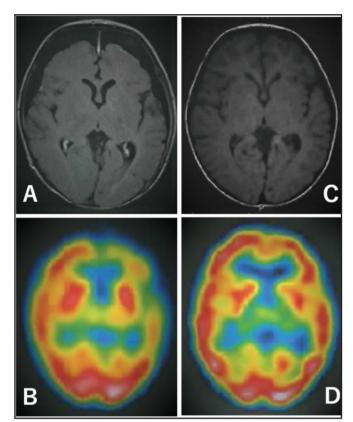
Magnetic resonance imaging (MRI) and 99mTc ethylcysteinate dimer-single photon emission computed tomography (ECD-SPECT) A: Fluid-attenuated inversion recovery brain axial MRI showing subdural abscess of the patient at day 17 of hospitalisation. B: ECD-SPECT showing an area of hypoperfusion that is observed predominantly in the left frontal to temporal region of the patient at day 17 of hospitalisation. C: Brain axial T1weighted MRI showing improvement of frontal subdural abscess at 3 years of age. D: ECD-SPECT showing improvement in cerebral blood flow at 3 years of age.
